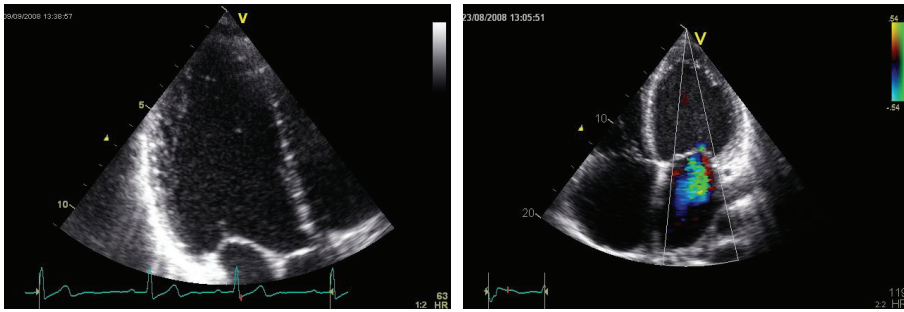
Left figure: Apical long axis view of left ventricle in healthy individual. Right figure: Colour Doppler revealing moderate mitral regurgitation in an individual with dilated cardiomyopathy.
